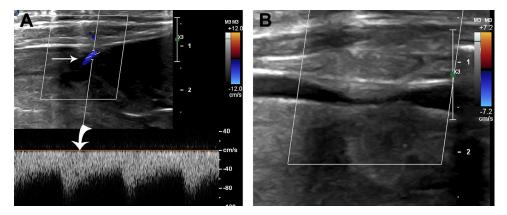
Doppler ultrasound images at the site of paracentesis before (A) and after (B) periarterial injection of thrombin. (A) Color flow (straight arrow) and arterial waveform (curved arrow) consistent with active arterial bleeding into the peritoneal cavity. (B) Post-thrombin injection images showing cessation of color flow.
